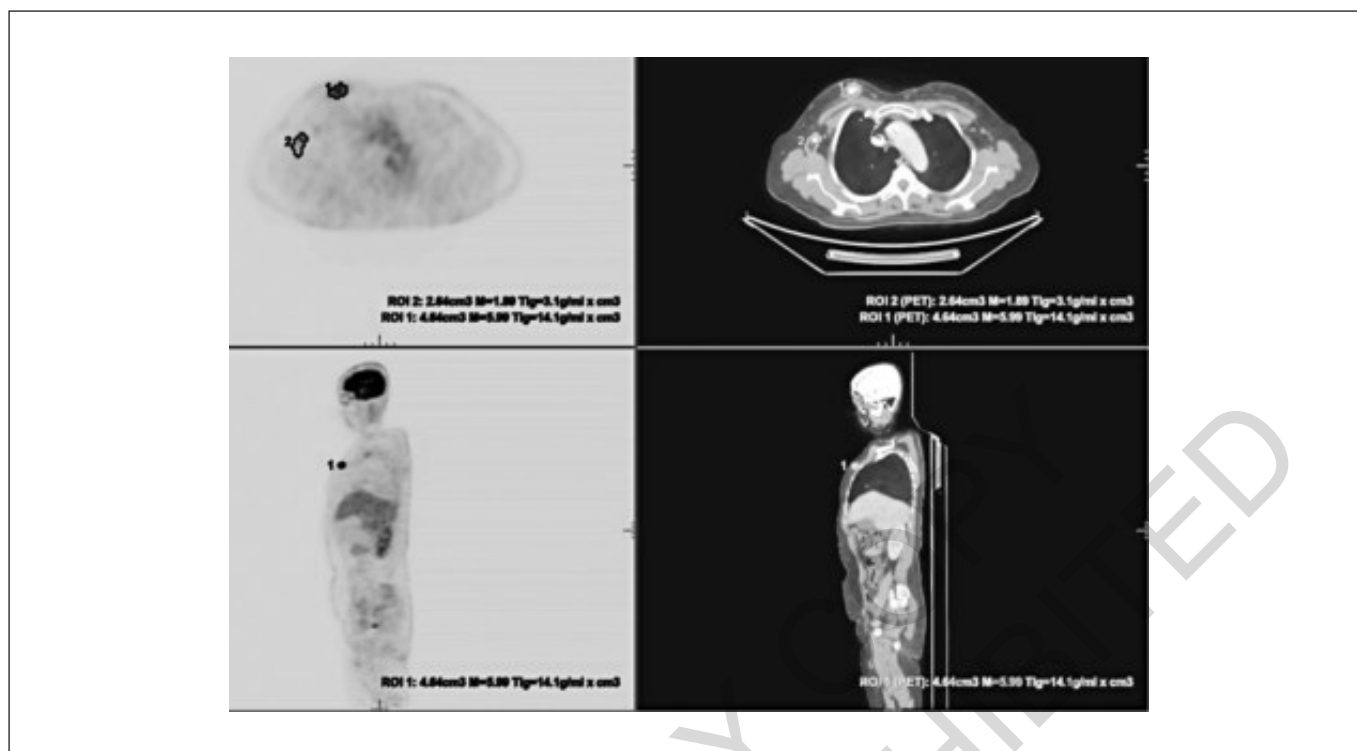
A 65-year-old patient who has invasive ductal carcinoma and a positive axillary lymph node; breast MTV: 4.64 cm<sup>3</sup>, breast TLG: 14.1g/ml.cm<sup>3</sup>, breast SUVmax: 5.99, axillary MTV: 2.64 cm<sup>3</sup>, axillary TLG: 3.1g/ml.cm<sup>3</sup> axillary SUVmax: 1.89, Total MTV: 7.28cm<sup>3</sup>, total TLG: 17.2g/ml.cm<sup>3</sup> CEA: 1.36g/ml CA 15-3: 19.75U/ml
